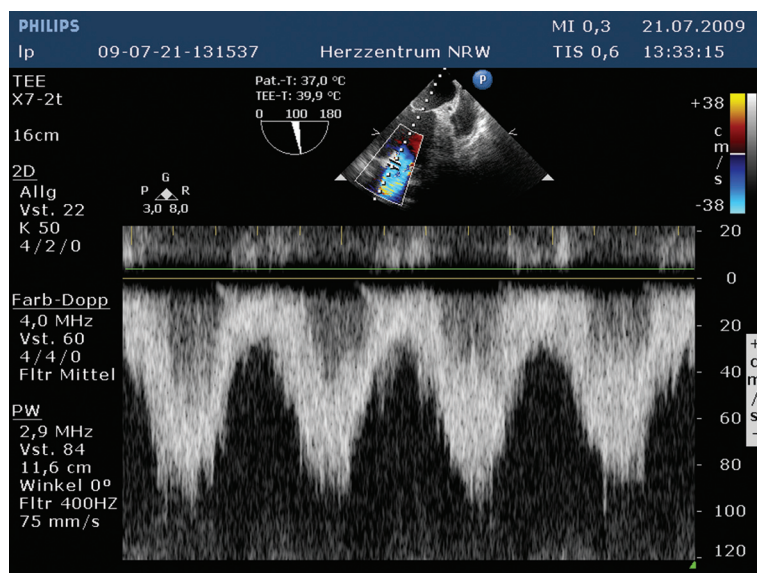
PW and CW Doppler transesophageal echocardiographic examination. Flow velocity pattern across the inflow (a) and outflow cannula (b).
